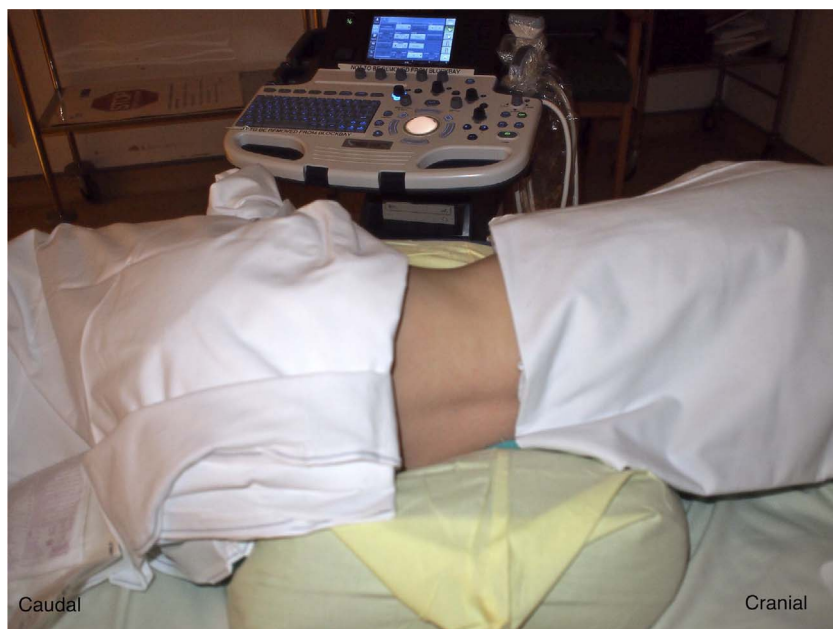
Ultrasound and patient position. In this picture, the patient is in the right lateral decubitus position.
